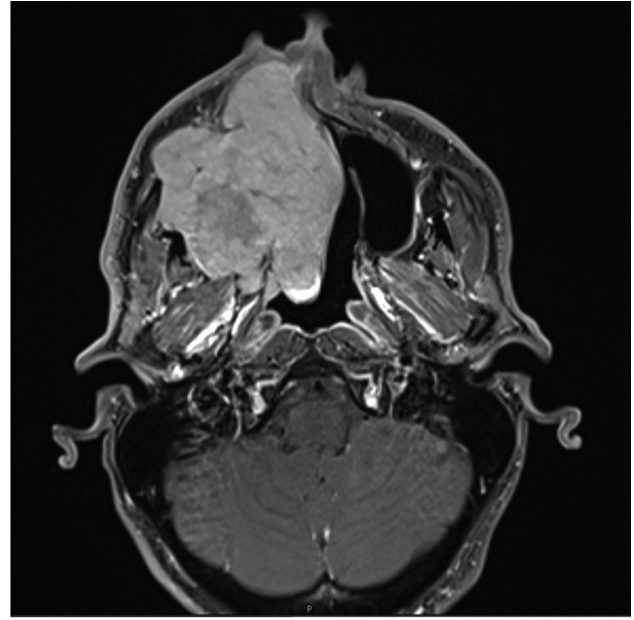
Preoperative magnetic resonance imaging (MRI) – Axial view. T1-weighted MRI with contrast medium of an axial section showing the length and width extent of the contrast-enhancing inhomogeneous tumor of the right maxillary sinus.
